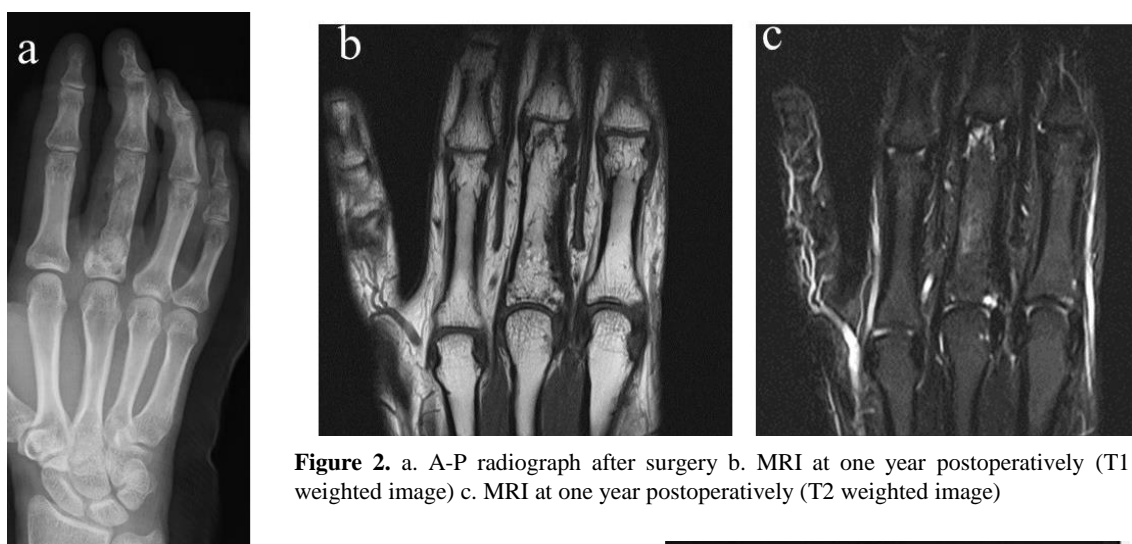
a. A-P radiograph after surgery b. MRI at one year postoperatively (T1 weighted image) c. MRI at one year postoperatively (T2 weighted image)
